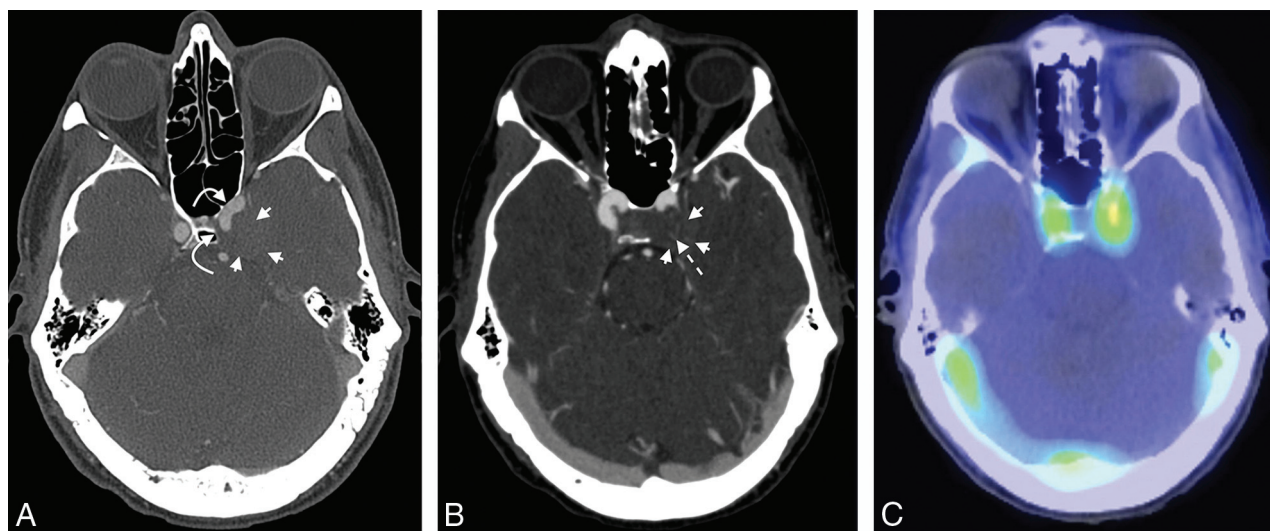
Preoperative CTA (A and B) demonstrates prominent bony remodeling about the margins of the mass (*curved arrows*). The mass itself is essentially isodense to the parenchyma (between the *short straight arrows*). Its inferior border is close to but does not appear to originate from the petroclival fissure (not shown). Small enhancing intrasignal vessels are appreciated (*dashed arrow*). A subsequent technetium Tc-99m-tagged RBC SPECT scan (C) shows intense radiotracer accumulation within the mass on delayed images.
